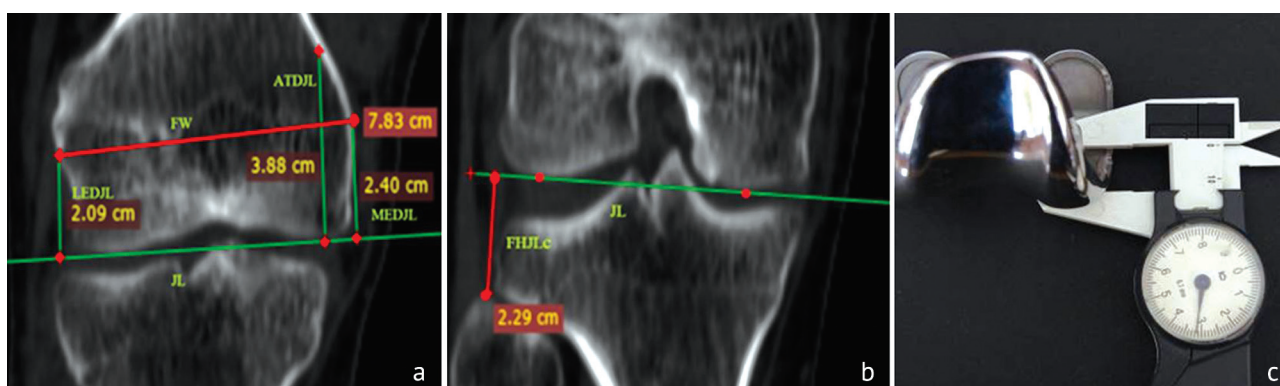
CT scan of the knee joint, frontal projection, presurgical planning: (a) determination of the level of the knee space using the anatomical landmarks of the femur; (b) along the top of the fibular head; (c) the thickness of the femoral component measured
